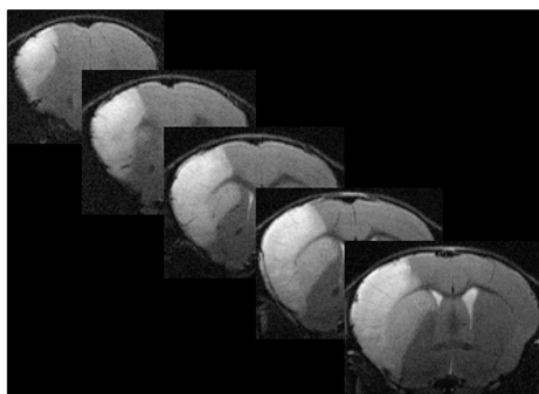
The representative images of brain infarction identified by MRI (representative T2 images).
